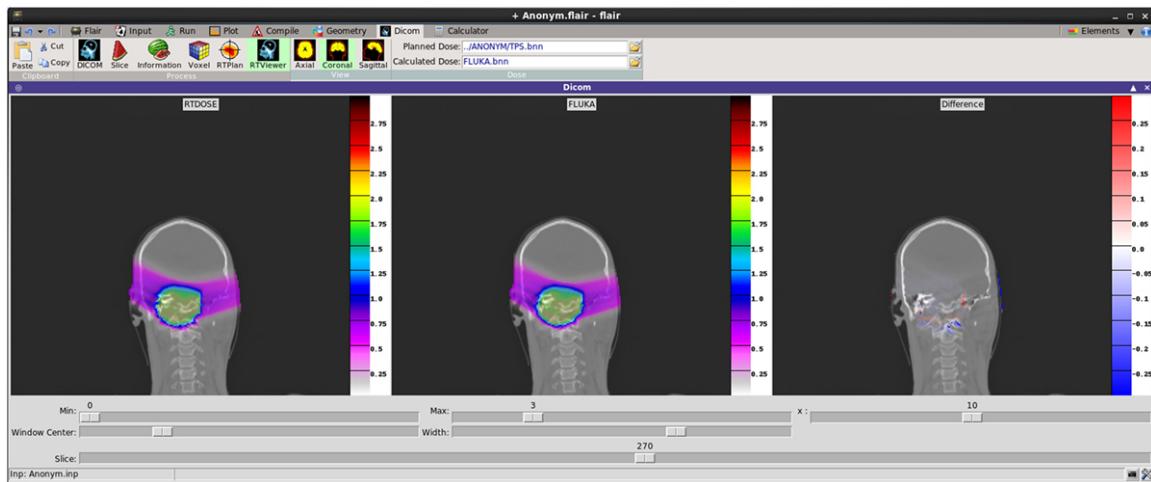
New DICOM RT interface. Coronal CT plane with mapped physical dose [Gy] from RT DOSE and FLUKA calculations. On the right, the differences between the obtained values [Gy]. *Published in [16].*
